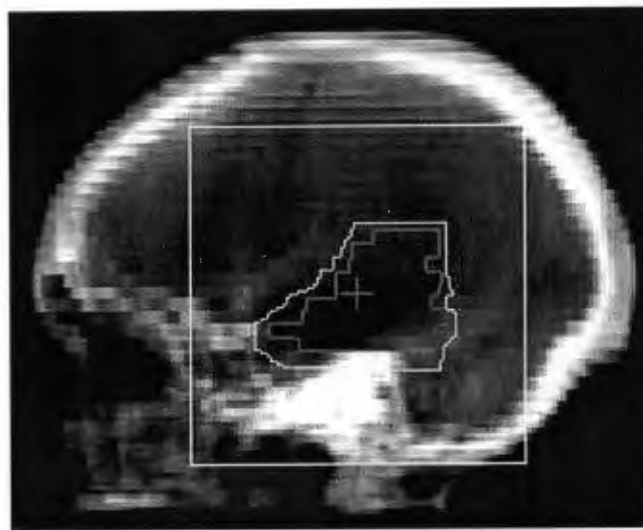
A digitally reconstructed radiograph obtained from the treatment planning system for the same beam and patient used for the X-radiograph in Figure 1-6.
